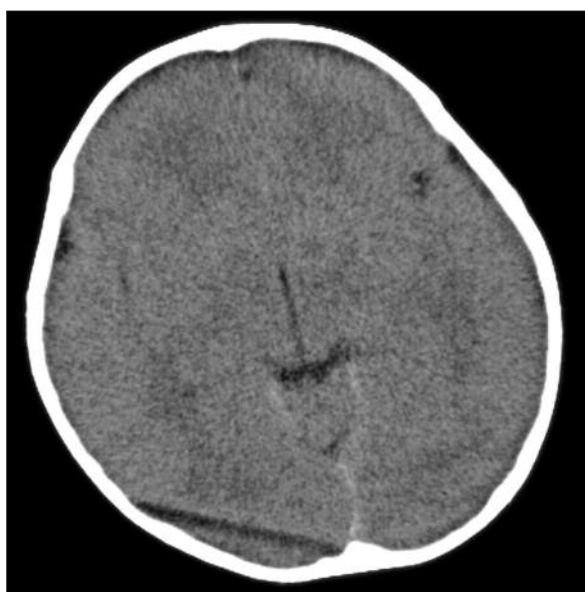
Cephalic CT on the first day on hospitalization. CT revealed severe form of diffuse cerebral edema.
